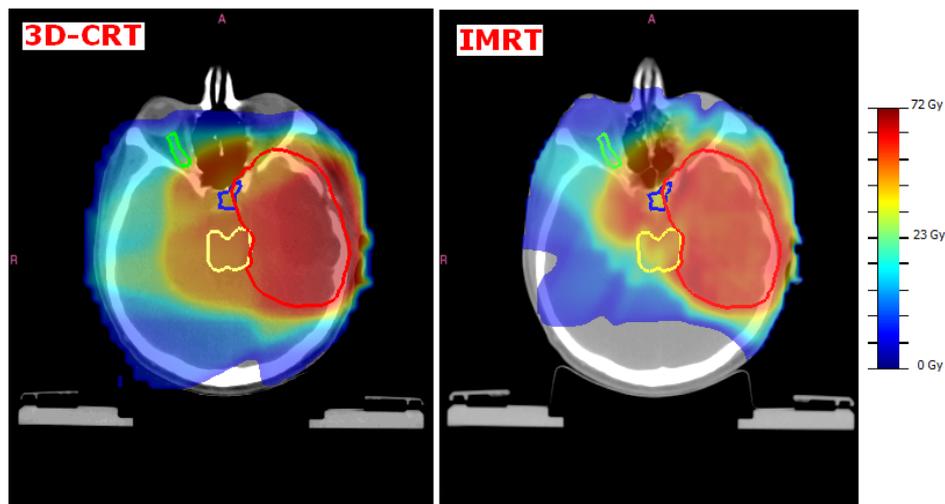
Comparison between 2D dose distributions produced by 3D-CRT and IMRT plans, respectively. One can see the better dose conformity around PTV (red) provided by IMRT as well as an improved avoidance of the brainstem. Furthermore, IMRT allows to reduce the healthy brain dose with respect to 3D-CRT. The high dose region outside of the target is due to the changing shape of PTV in the neighbouring slices of the CT scan.
